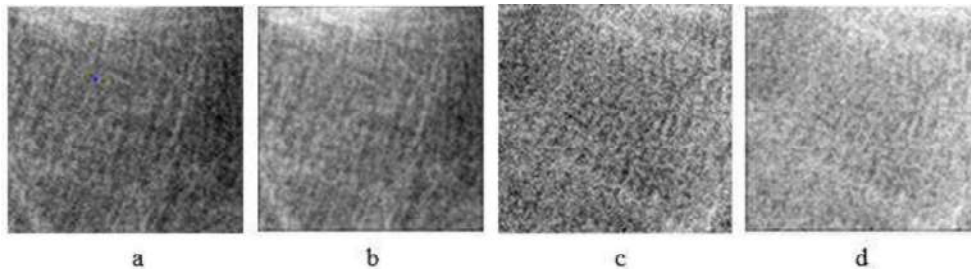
Filtering. Original ROI from KL 0 knee radiograph (a), filtered ROI from KL 0 knee radiograph (b), original ROI from KL 2 knee radiograph (c), filtered ROI from knee radiograph of KL 2 (d).
